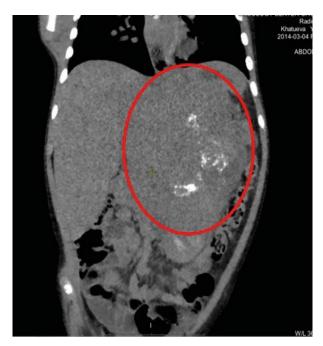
CT scans before 6 courses of polychemotherapy of patient K. The primary prevalence of the tumor before induction polychemotherapy.
